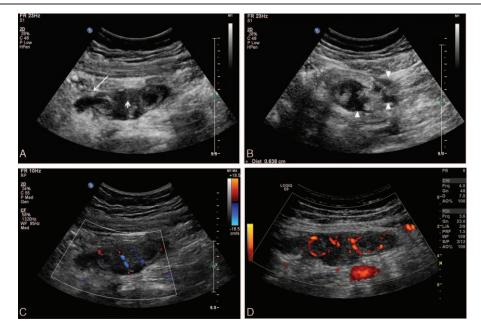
The longitudinal view of abdominal ultrasound (A) of reveals a suspected lesion (arrow) in the body of the appendix. Its characteristics are inhomogeneous, hypoechoic, ill-defined. Appendiceal ostium is marked by the arrowhead. Its transverse scanning (B) showing the posterior wall of the lesion is locally broken measuring about 6 mm in width and a smaller area of fluid surrounding the lesion and the appendix is marked as triangle sign. Color Doppler (C) and Power Doppler (D) show plenty of linear blood signals intra-lesion.
